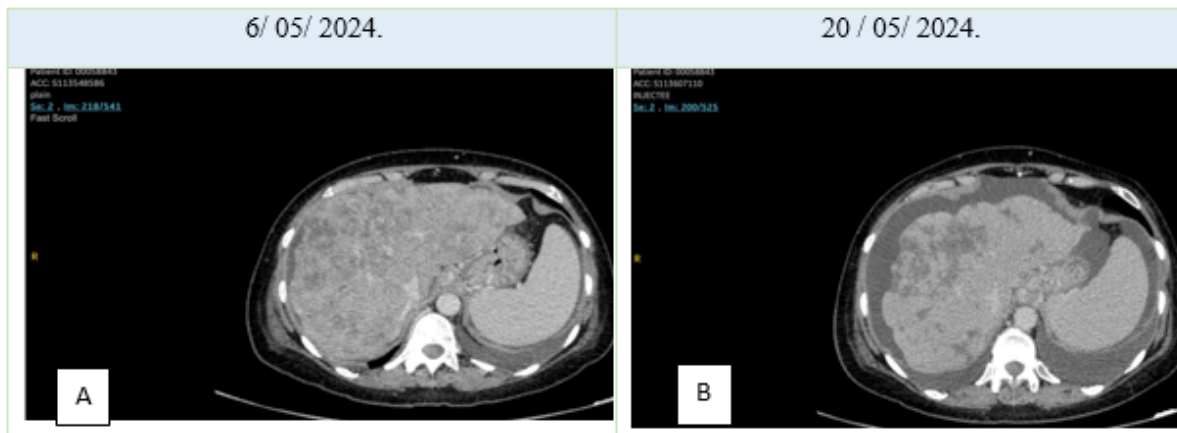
Comparative computed tomography abdominal scan of liver metastases before and after the initiation of Trastuzumab-Deruxtecan. A: Before the rechallenge with trastuzumab deruxtecan: Multiple metastatic lesions of both hepatic lobes predominantly in the right hepatic lobe with hepatomegaly and a perihepatic effusion. B: After one cycle of Trastuzumab-Deruxtecan: Important regression of the multiple diffuse secondary heterogeneous lesions of both hepatic lobes, with remaining sequelae hypo dense lesions and fibrotic changes deforming the liver contours. Changes indicative of a clear response evaluated to more than 50%.Dr Lina Menassa, Radiologist at Hotel Dieu De France Hospital.
